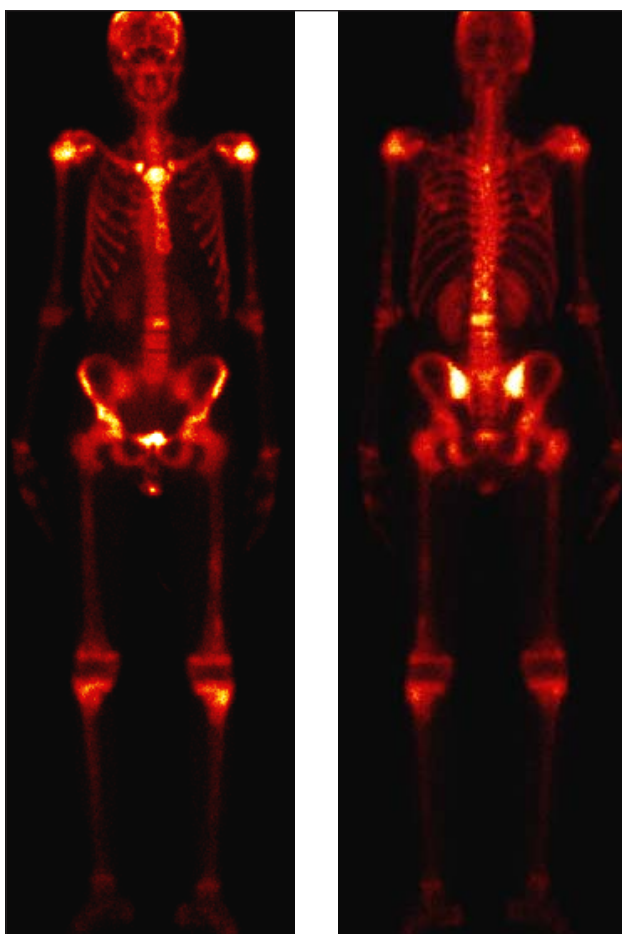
Tc99-scintigraphy with high accumulation at the skull, right clavicle, bilateral humers, L3 of spinal cord, pelvis bones and bilateral femurs.
